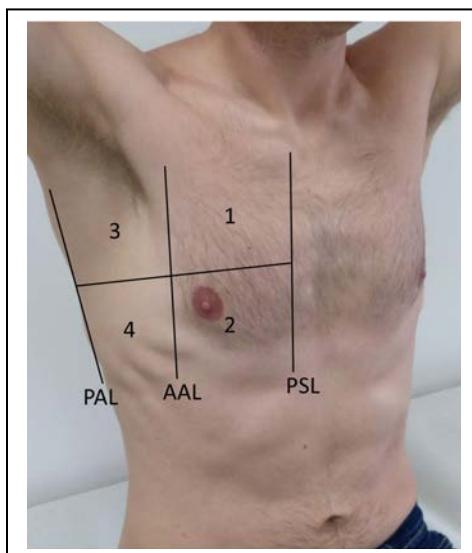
Lung ultrasound protocol including eight regions, four bilaterally, for evaluation of the interstitial syndrome. PAL=posterior axillary line, AAL=anterior axillary line, PSL=parasternal line.
